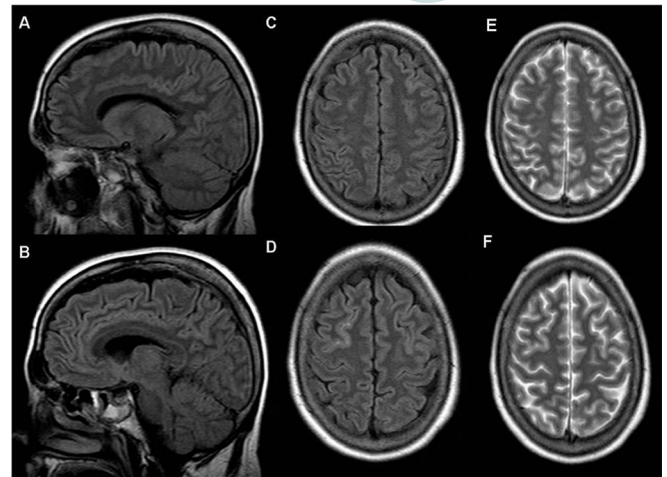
Sagittal fluid-attenuated inversion recovery (FLAIR) (A, B), axial FLAIR (C, D) and T2-weighted images (E, F) one month later, showed near total remission of the lesions.
